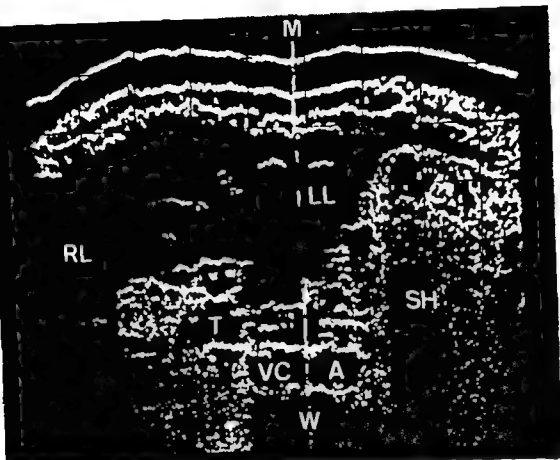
Ultrasonic scanning (Dr G Engelhardt, Department of Medicine, University of Basel). The transverse ultrasonic tomography shows the liver (RL), the vena cava (VC), aorta (A) and the gastric
